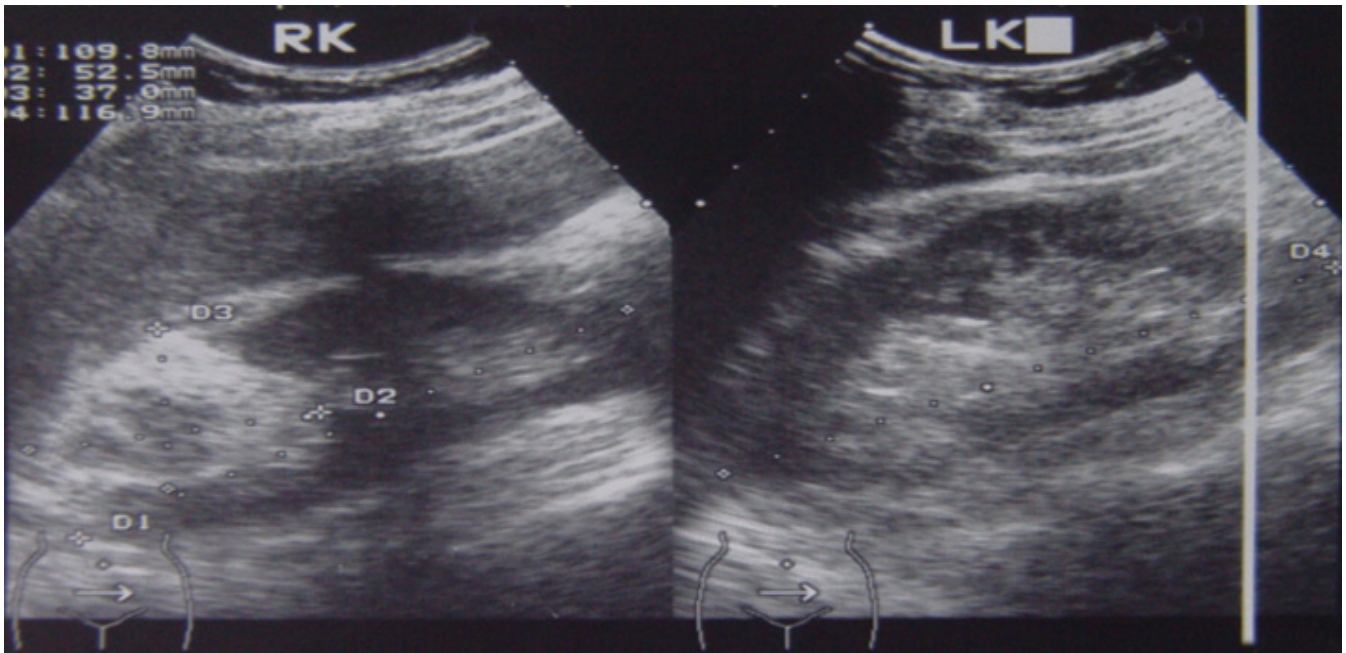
Sonogram shows hyperechoic renal mass in upper pole of right kidney with round hypoechoic intratumoral area.
